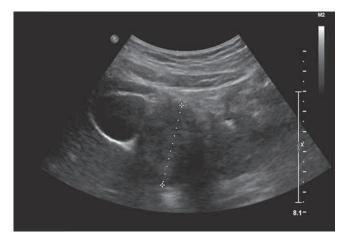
Transabdominal ultrasound in a 49-year old man shows a 5-6 cm mass between the pancreas and gallbladder. The mass could not be clearly delineated from the duodenum and pancreatic head and contained several small calcifications and cysts (not seen on this image).
